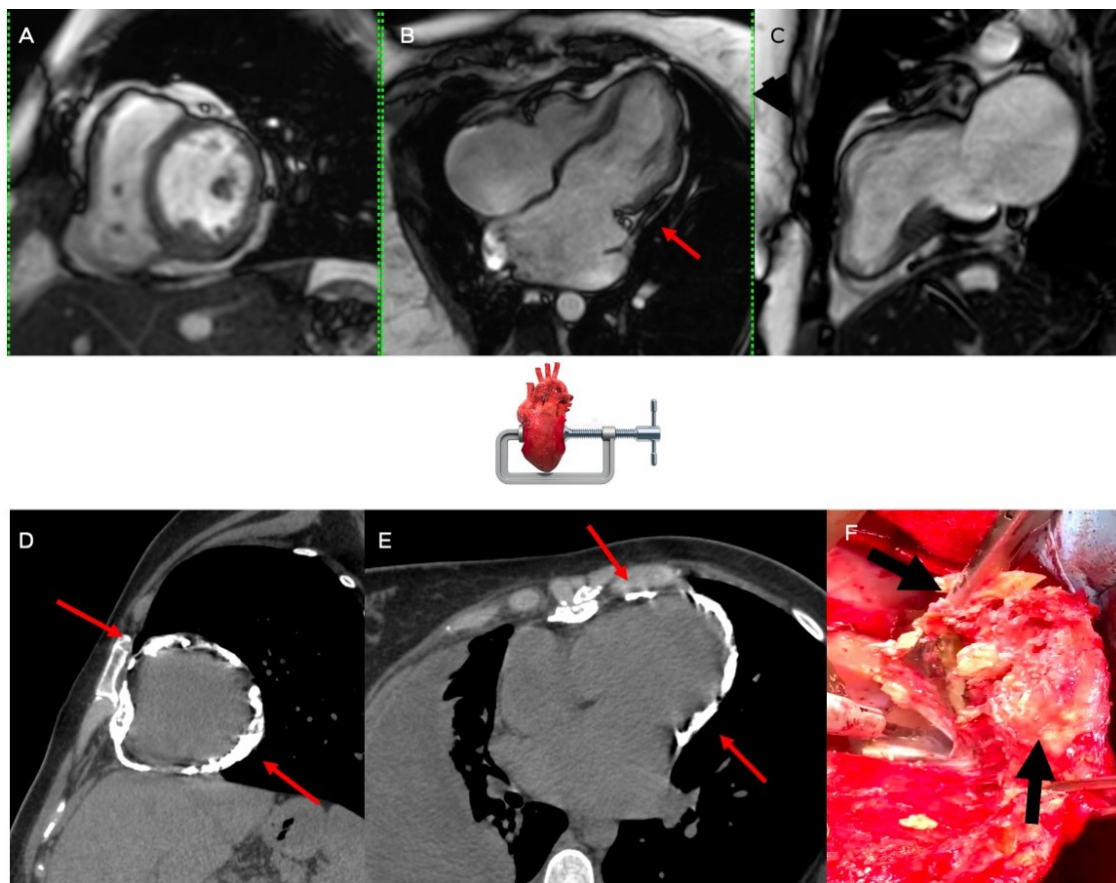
(A-F): 41-years old with breathlessness. The cine cardiac images (A – short axis, B – four chamber and C - two chamber) showed normal systolic function. Note the banana shaped LV and RV on the four chamber view, which suggests constriction along the basal LV. Marked thickening however is not seen. Biatrial dilatation is seen. The short axis CT scan image (D) shows circumferential chunky calcification at the level of the atrioventricular groove, encircling both ventricles from apex to base as also seen on the four chamber CT scan image (E) – this is barely appreciated on the MRI. At surgery, a thick peel of calcified pericardium was removed (arrows in F) (image courtesy Dr. Z Hamdulay). It is as if the heart is caught in a vise as depicted in the central image.
